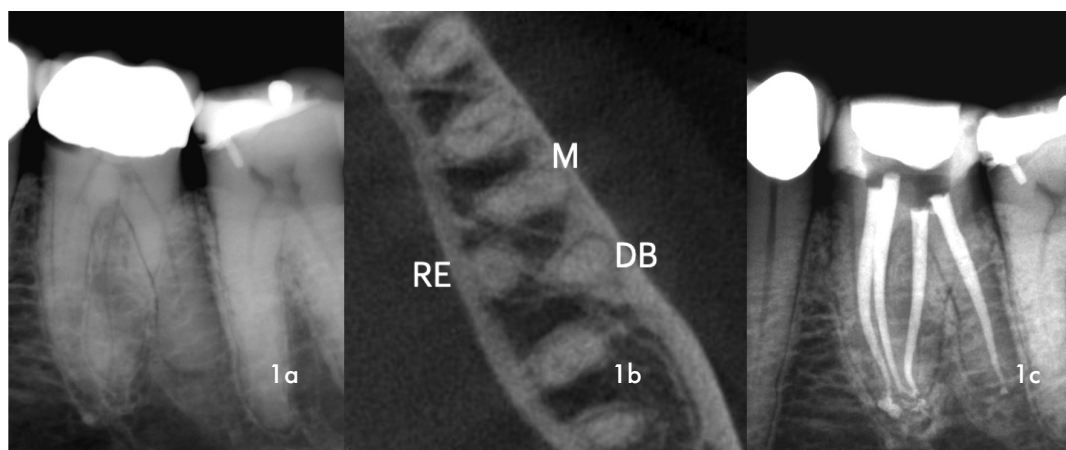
(a) Pre-operative radiograph of mandibular, left first permanent molar that was restored with a ceramo-metal crown, showing evidence of decay on the mesial gingival margin (b) CBCT- midroot axial view revealed the presence of a mesial root (M), distal (D) and Radix Entomolaris on the lingual aspect (RE) (c) A 30 degrees, mesial angulated view of the four obturated root canal systems.
